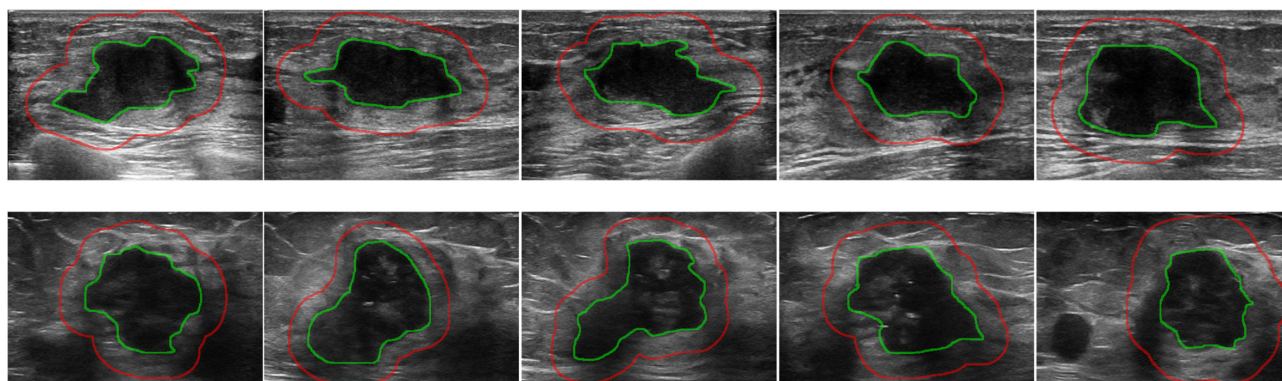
Examples of ultrasound slices overlapped with intratumoral regions (green) and peritumoral regions (red) from two patients. (Top) A patient with positive ALN. (Bottom) A patient with negative ALN.
